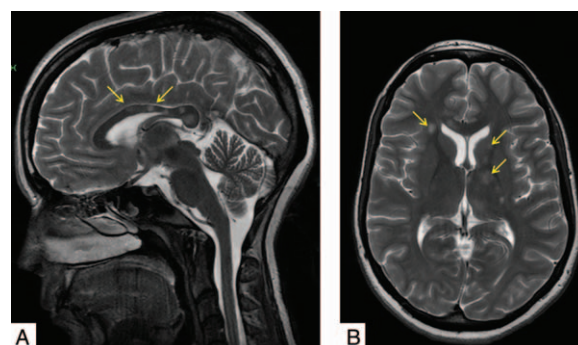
MRI scans of patient number 3. (A) Corpus callosum lesions (arrows). (B) Periventricular lesions (arrows).
